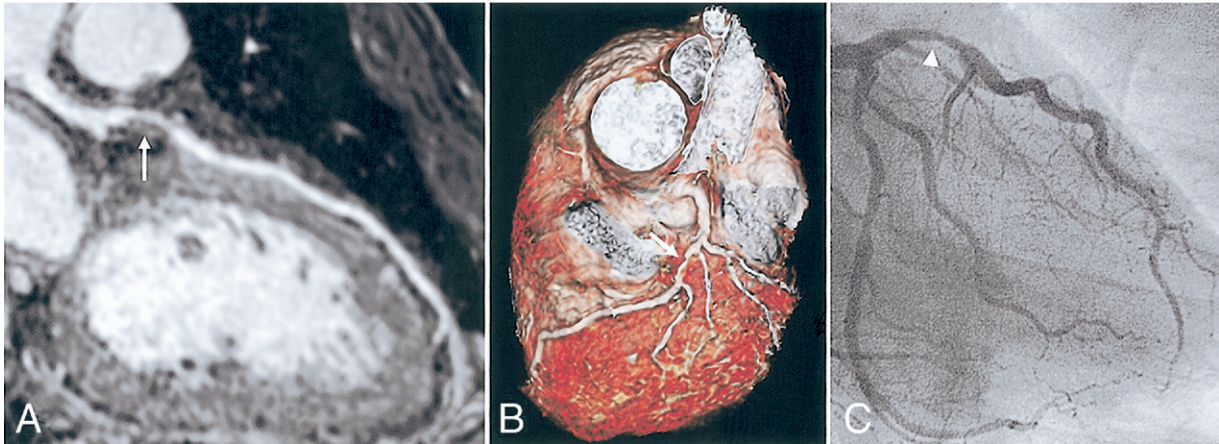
Visualization of a stenosis in the left anterior descending artery (LAD) with whole-heart coronary magnetic resonance angiography. (A) Curved multiplanar reconstruction image shows a stenosis in LAD (white arrow). (B) Volume-rendering method demonstrates 3-dimensional view of LAD with stenosis (white arrow). (C) X-ray coronary angiography reveals a stenosis of proximal LAD (arrowhead).
